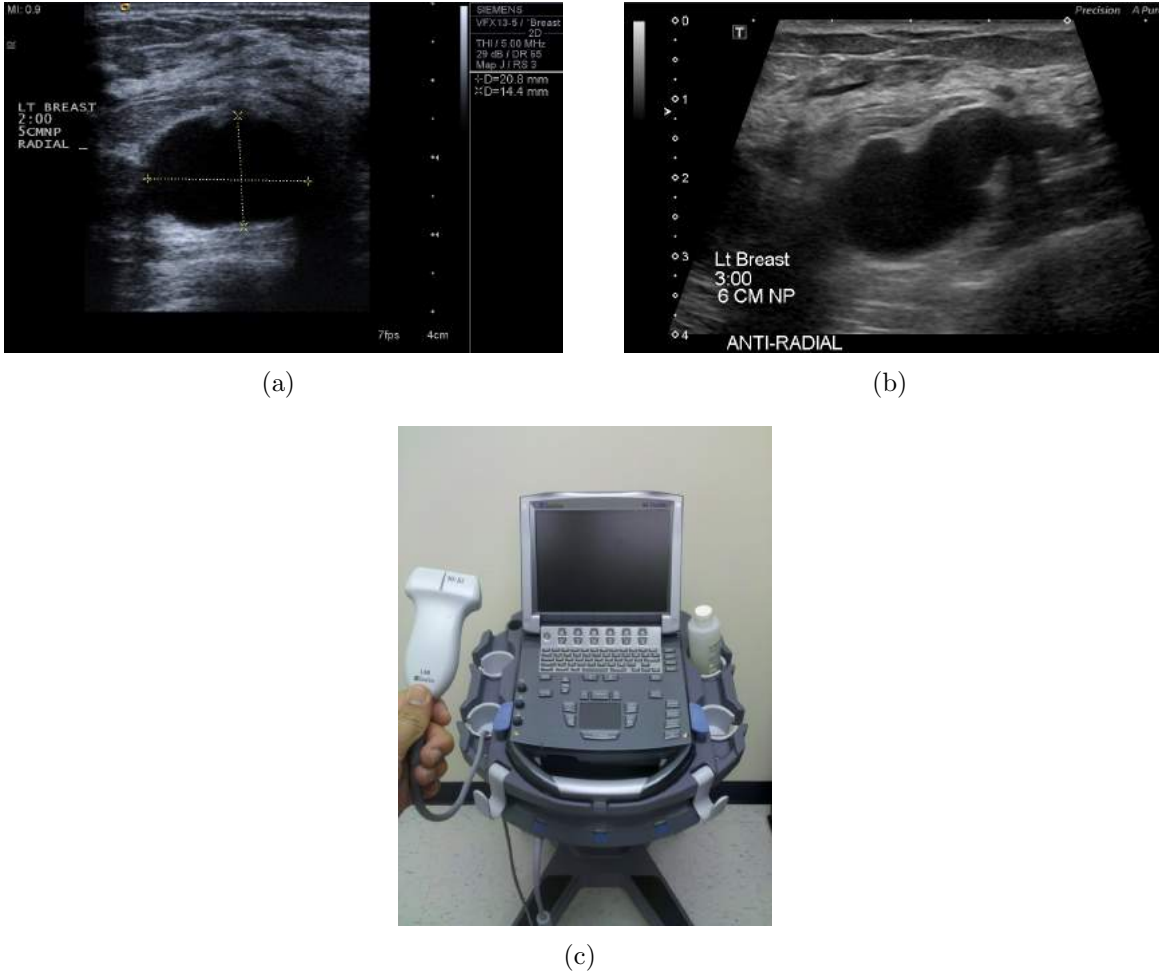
Hand-Held Ultrasound (a) Example of reflection or B-mode image. (b) Example of reflection or B-mode image from another scan at a later time corresponding to the approximate location in (a). (c) Data acquisition.
